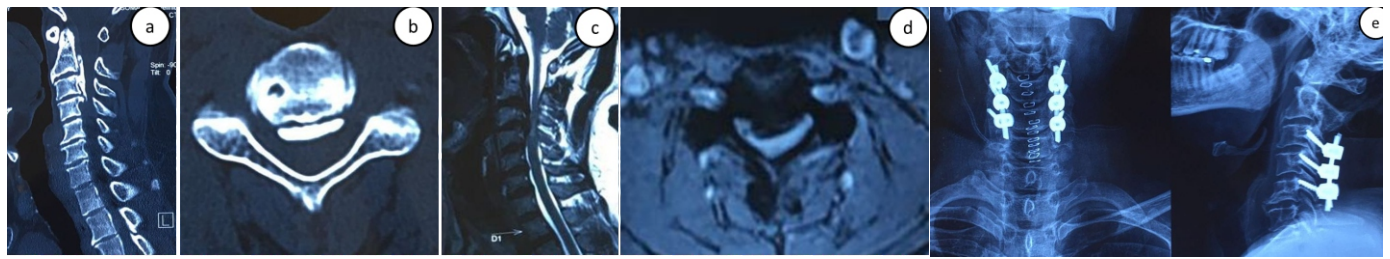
a- preoperative MRI scan, b,c-preoperative CT scan, d-postoperative CT scan, e-Postoperative MRI scan
